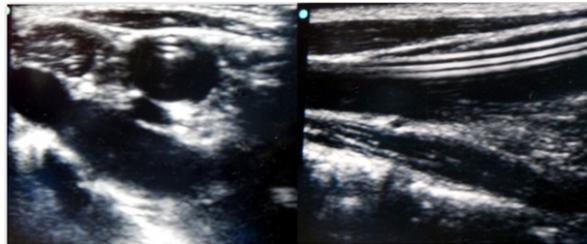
Ultrasound appearance of central venous catheter
